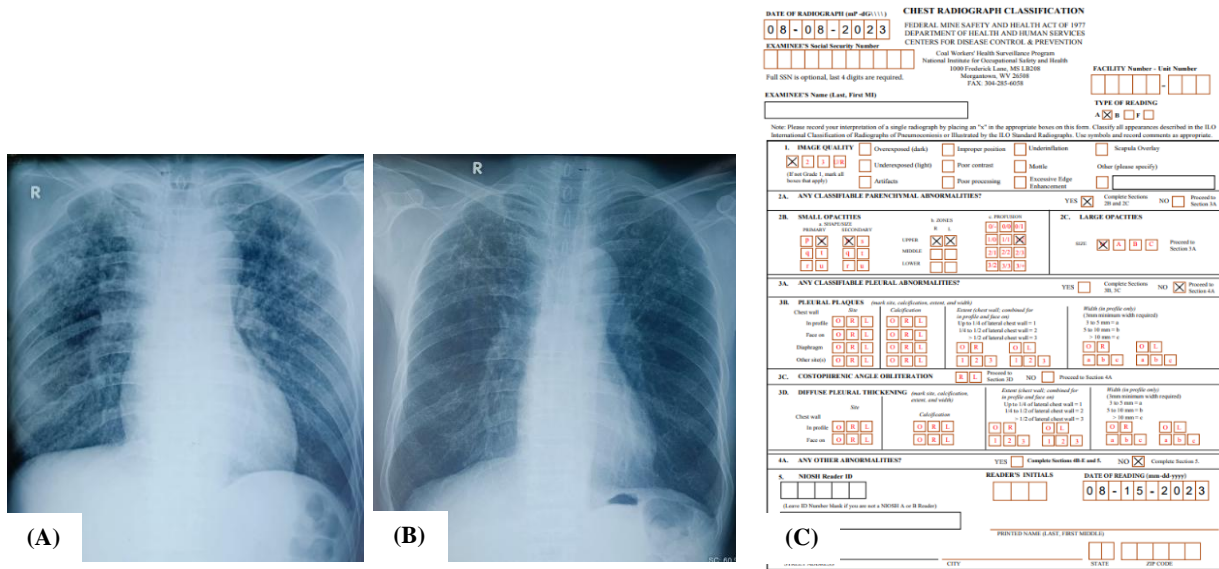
A) Chest X-ray in anterior-posterior position on the first day of hospitalization; B) a high-kV chest X-ray two months following tuberculosis therapy; and C) the International Labour Organization reading sheet
